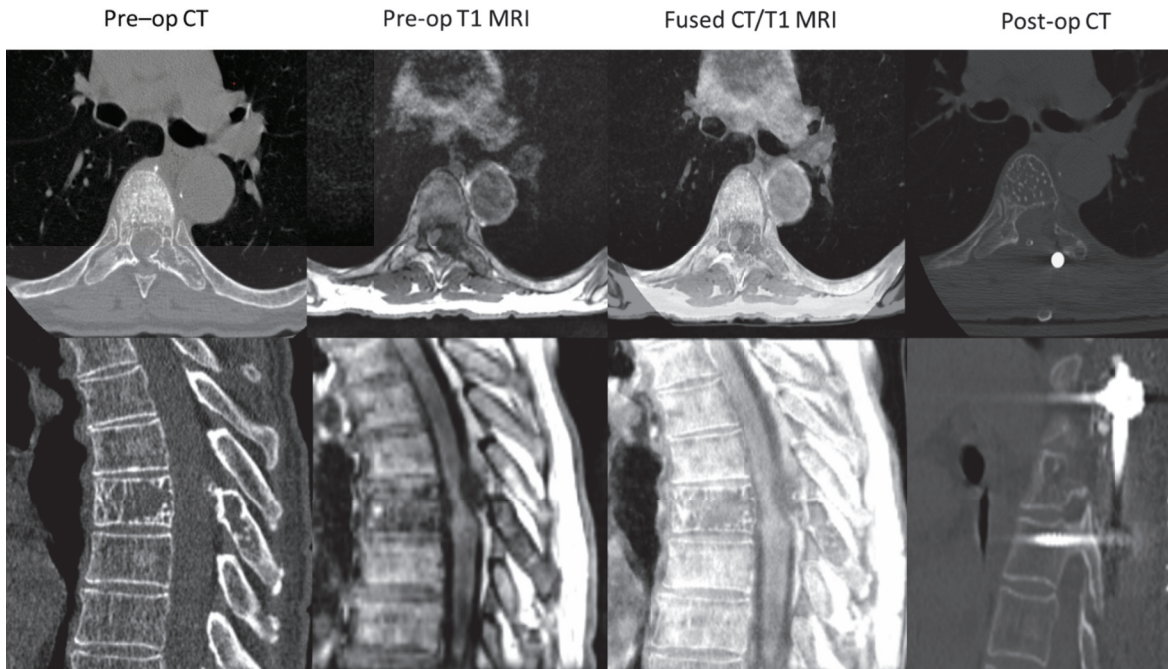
Patient 1: Clinical course – Patient with hemangioma with epidural extension and cerebrospinal fluid effacement causing spinal cord compression. T1 MRI was fused to CT for navigation. Postoperative changes seen on CT with unilateral instrumented fusion.
